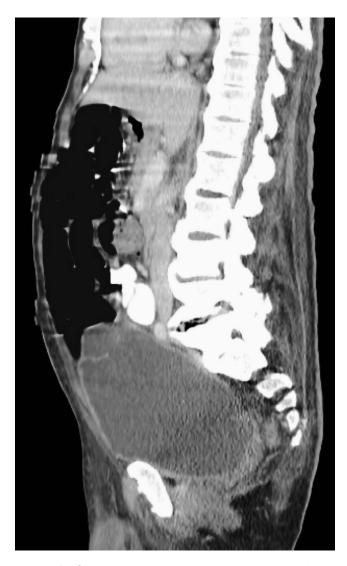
Computed tomography sagittal image of the abdomen and pelvis (with contrast) reveals marked distention of the bladder.
